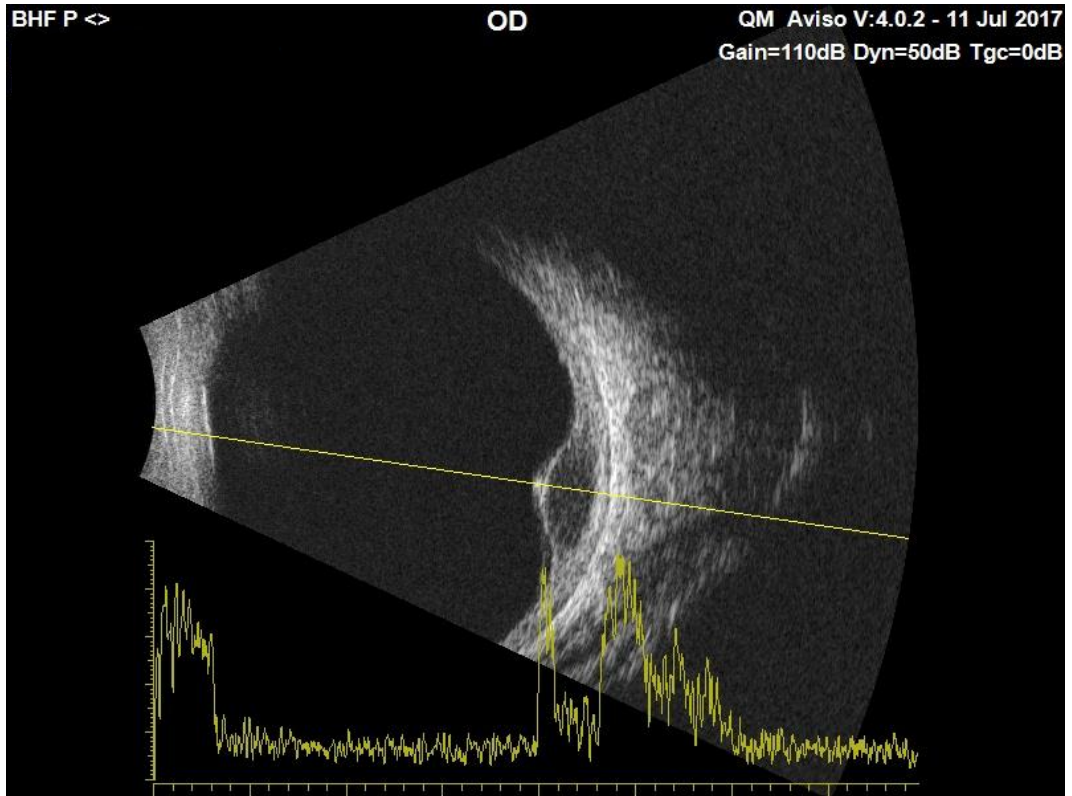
Ultrasonography (20 MHz probe) demonstrating low internal reflectivity of the lesion.
